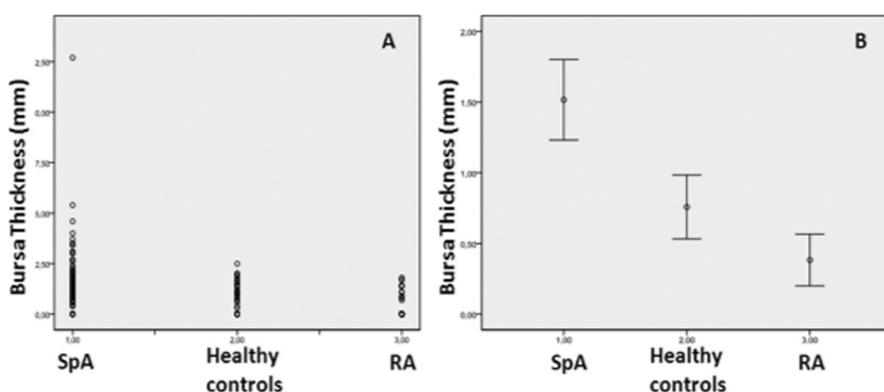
Ultrasound bursa measures in spondyloarthritis (SpA) and controls. A. Scattergram dots distribution in SpA, healthy controls and rheumatoid arthritis (RA) control group. B. Mean and 95%CI of bursa thickness in SpA, healthy controls and RA controls.
